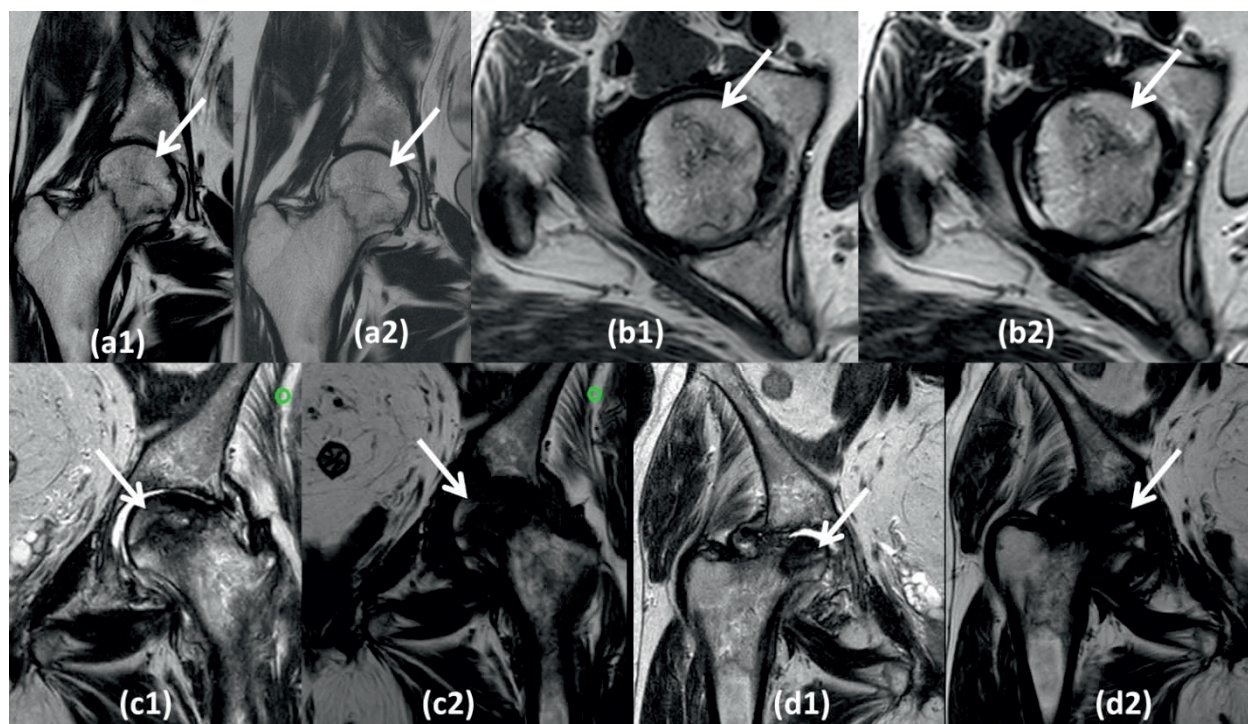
Paired T1 and T2 MR images with arrows demonstrating Mitchell classification of AVN femoral head.
